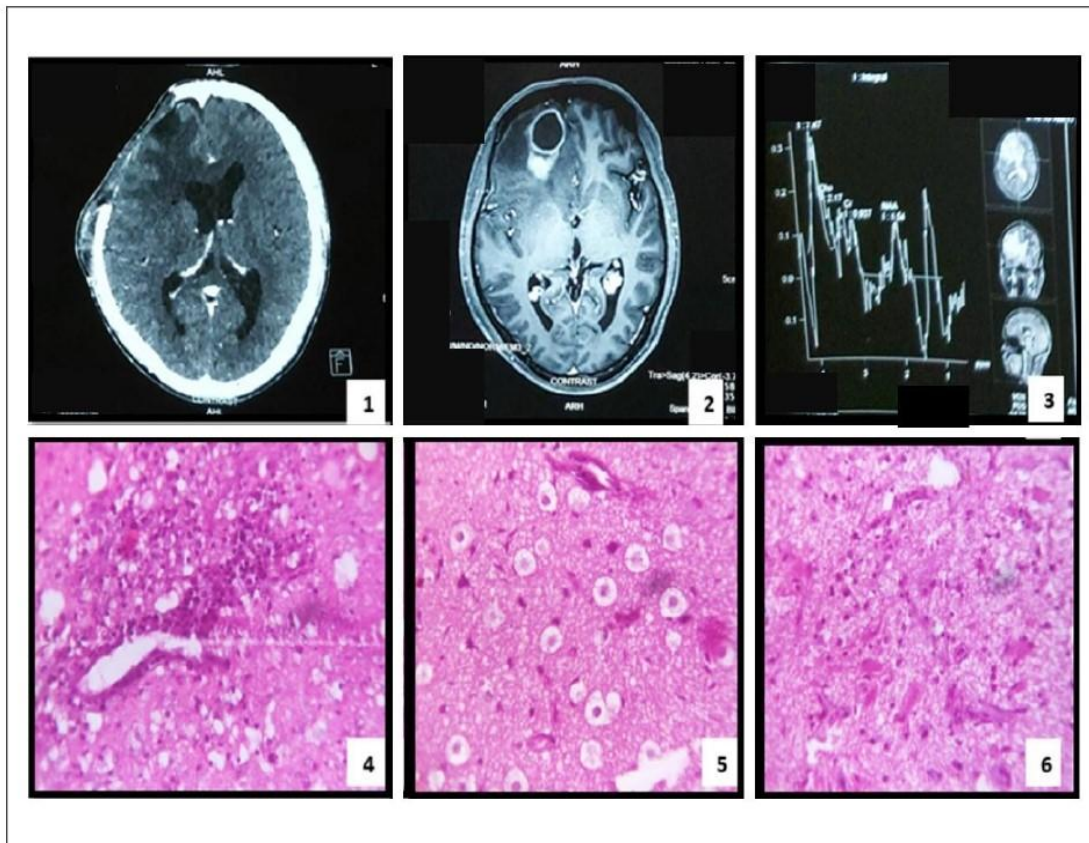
CT-scan brain showing ill defined hypodense lesion in the right high frontal region with peripheral vasogenic oedema involving genu of corpus callosum, right frontal region causing midline shift towards left with effacement of adjacent right lateral ventricle.
